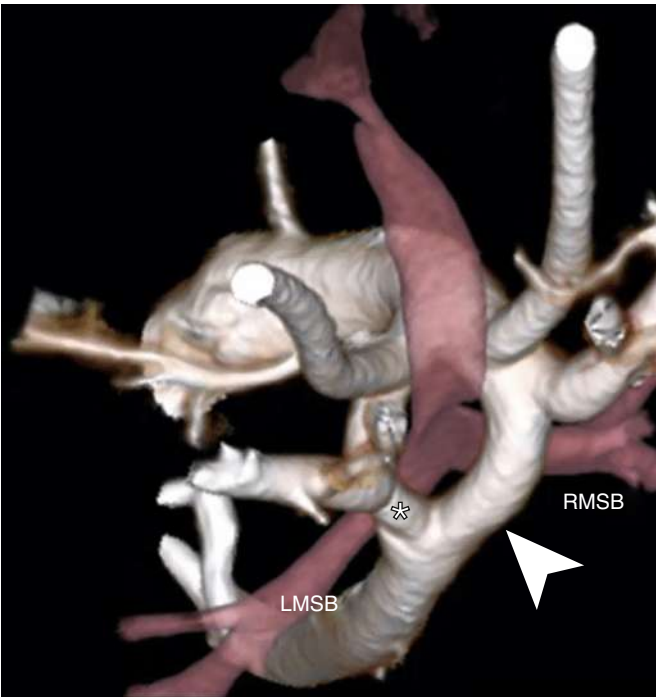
Double aortic arch in a 12-year-old. Superior (bird's eye view) three-dimensional volume-rendered CT image shows the larger dominant arch (arrowhead) on the right side, coursing over the right mainstem bronchus (RMSB). There is mild indentation of the trachea. The smaller left arch (asterisk) courses over the left mainstem bronchus (LMSB). (From Madueme PC: *Computed tomography and magnetic resonance imaging of vascular rings and other things: a pictorial review*. *Pediatr Radiol* 2022;52:1839–1848.(Fig. 2, p. 1840.)
